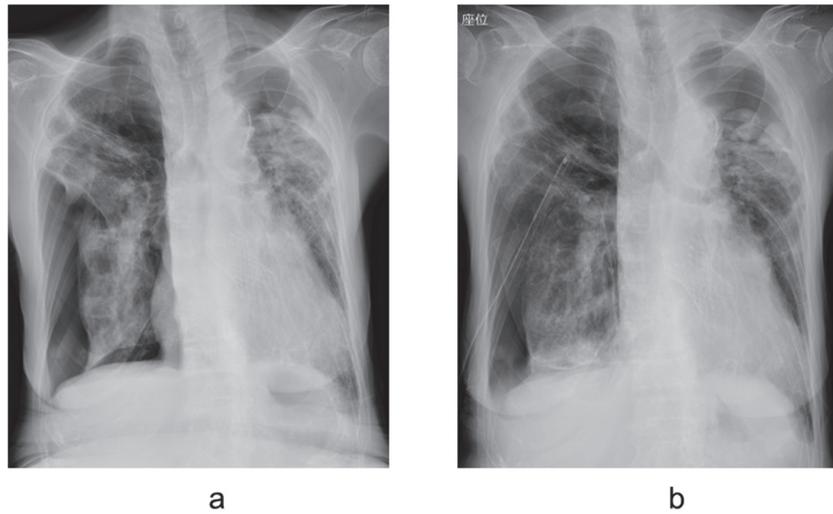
Chest radiograph on admission revealed a right pneumothorax (a). The lung expansion was not complete after multiple conservative therapies (b).
